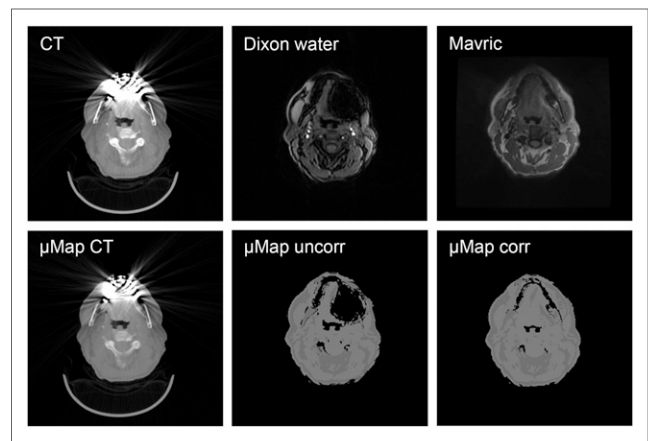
(Top) Typical examples of images obtained from low-dose CT, water dataset of Dixon sequence, and MAVRIC sequence are shown. (Bottom) Corresponding μ maps generated from CT, Dixon sequence alone, and new correction algorithm are shown.
